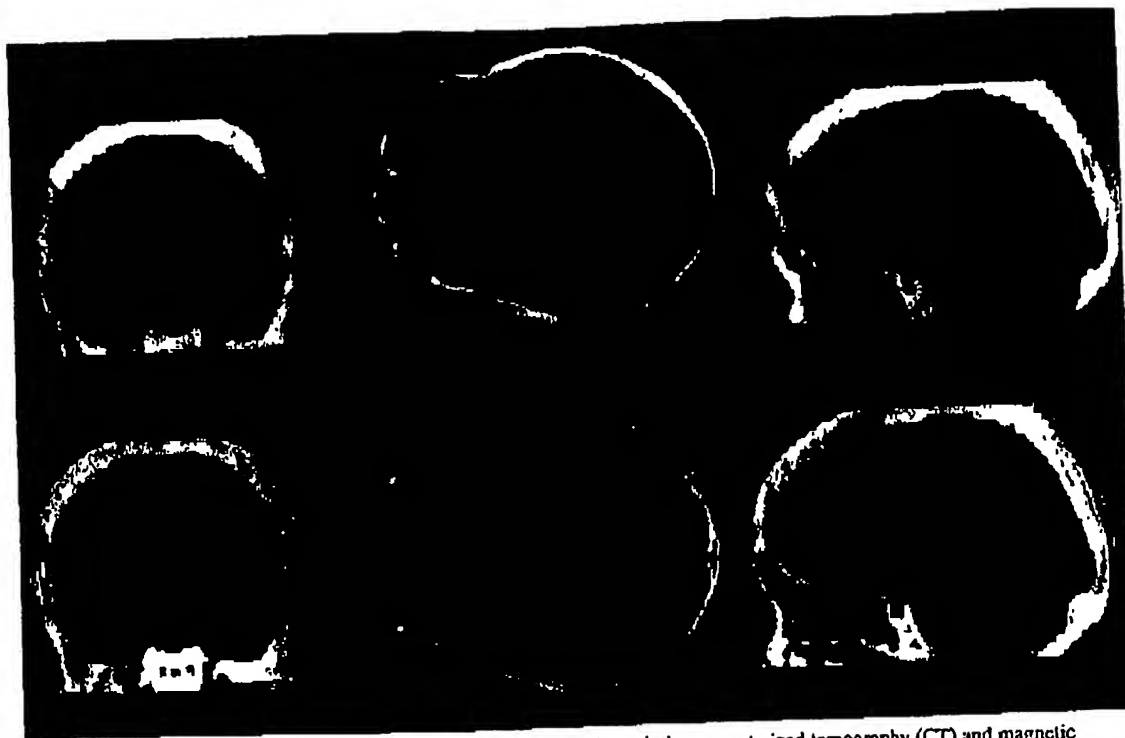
Coronal, transverse, and sagittal midplane sections through the computerized tomography (CT) and magnetic resonance (MR) volumes before (*upper*) and after (*lower*) the fusion process, demonstrating the CT coordinate system as the reference system. *Upper:* The MR image values are shifted superiorly and to the right compared with the CT bony anatomy. Note the gross misalignment in translation and rotation of the two volumes. The fusion process relies on the automatic segmentation of the surfaces of the bony anatomy in both CT and MR volumes. *Lower:* The bone surfaces from CT are aligned to the bone surfaces in MR using the chamfer matching method described in the text. Note the excellent agreement in the postfusion images between the CT anatomy and the MR anatomy as visualized by the soft-tissue components inside the skull, the bone edges with respect to the MR anatomy, and the sinuses.
